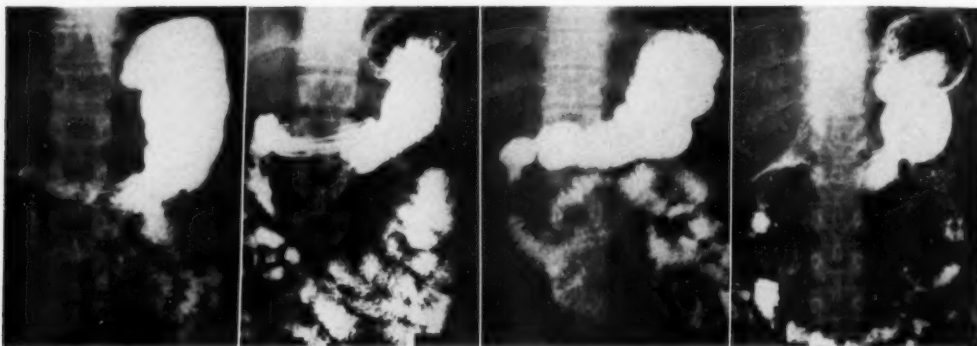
Roentgenograms of the stomachs of four individuals showing normal relationships between cardiac portion and the overlying diaphragm.
